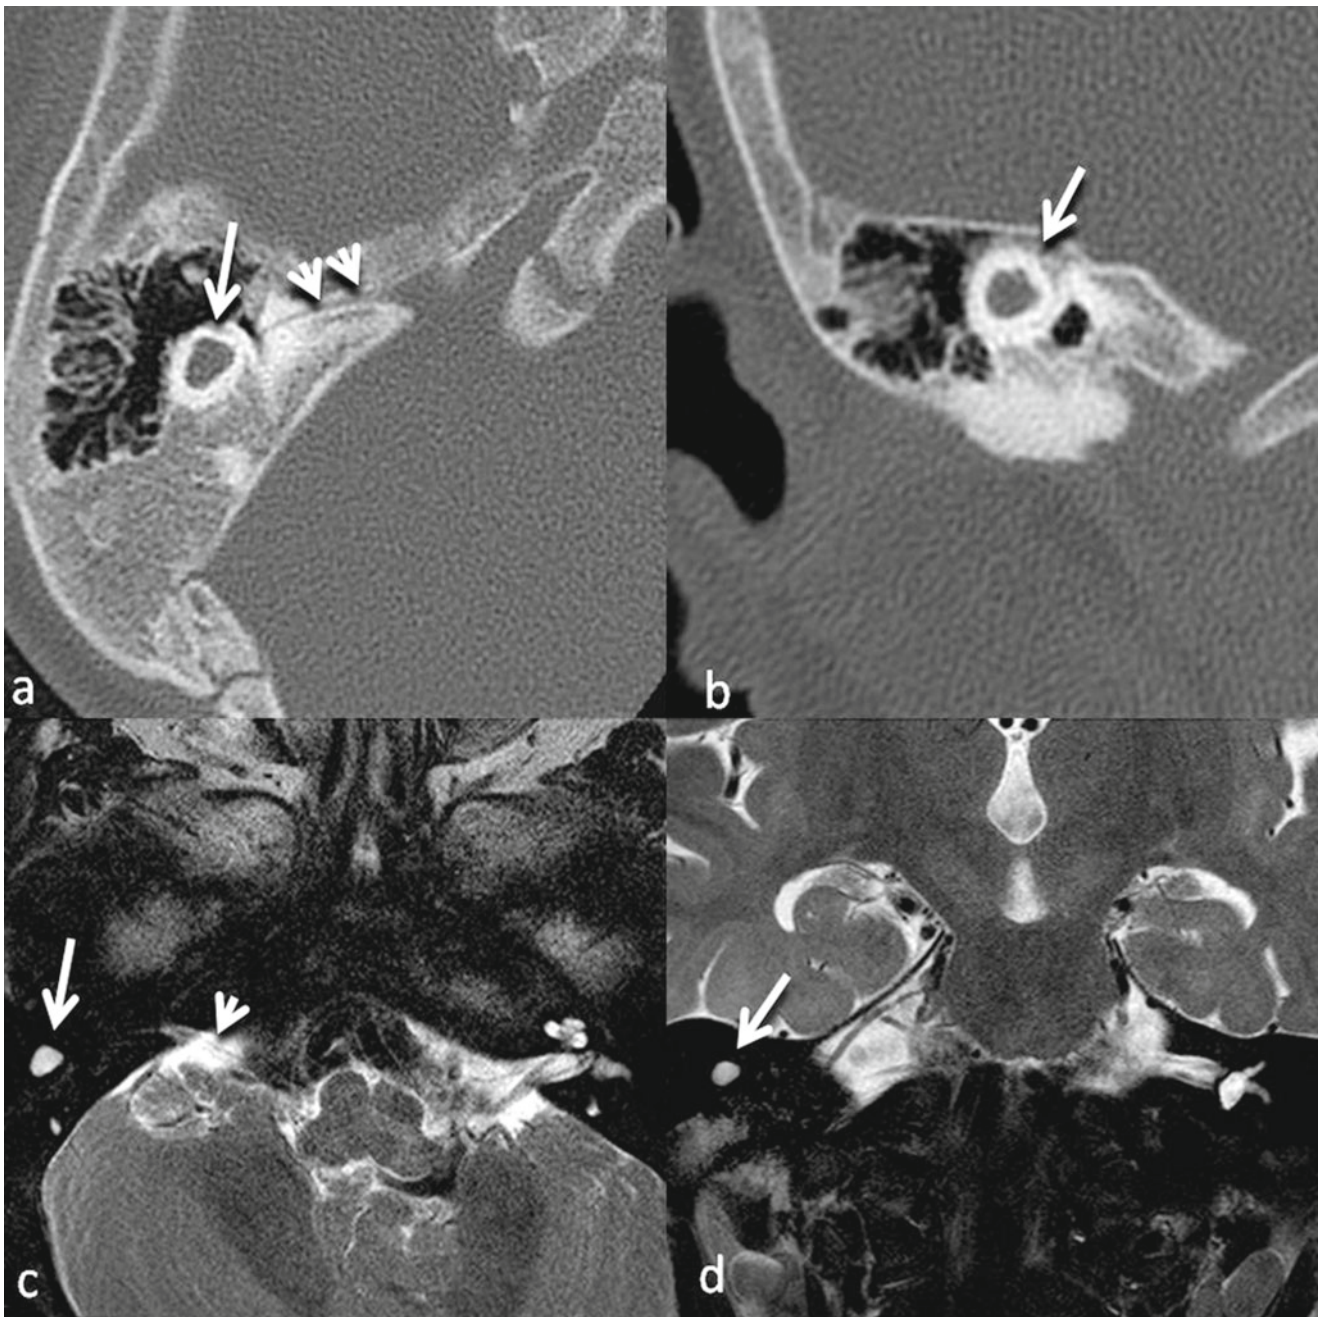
Imaging findings in a 14 month old with right profound loss and facial nerve paralysis. A right isolated otocyst remnant is present and left ear has normal anatomy. CT: (a) Axial view isolated otocyst (arrows) remnant and extremely small facial nerve canal (arrow heads)
